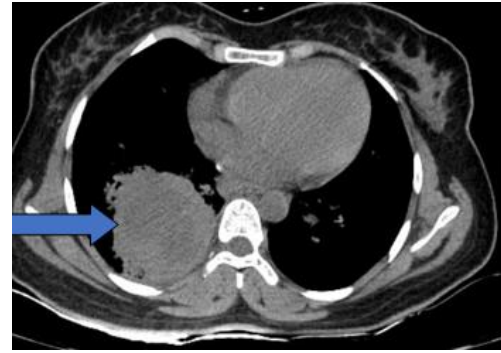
HRCT of the chest plain(axial view) showing a large well defined thick walled lesion(Blue arrow) in the posterior basal and medial basal segments of the right lower lobe with non enhancing central necrotic component.
